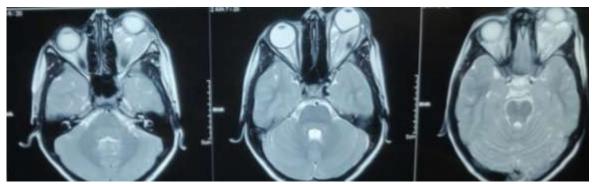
MRI Showing retro orbital swelling suggestive of lymphangioma
